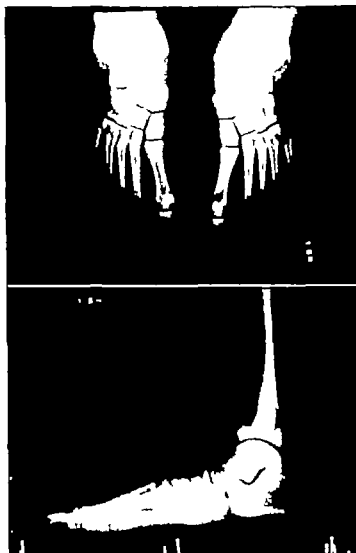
Roentgenograms of disabling flat feet See also Figure 13
